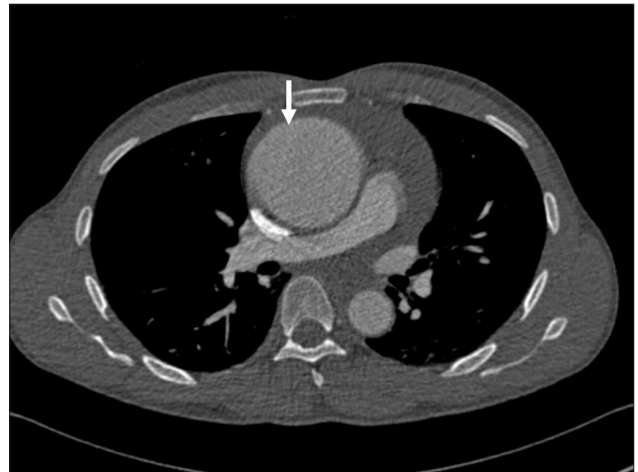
Contrasted computed tomography angiogram of the chest. The arrow marks the ascending thoracic aortic aneurysm (slice thickness 0.6 mm).
